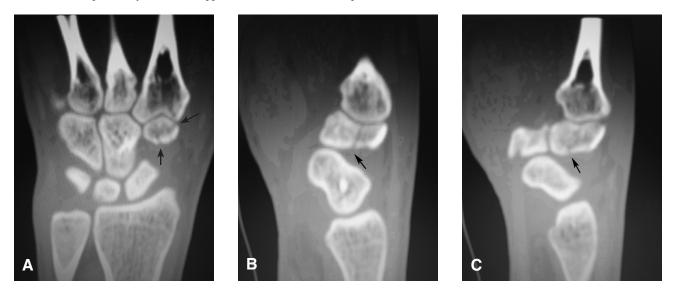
CT of the injured wrist. Coronal image (A) demonstrates a nondisplaced fracture line through the trapezoid (black arrow). Sequential sagittal images (B and C) verify the nondisplaced nature of this fracture (black arrows).
